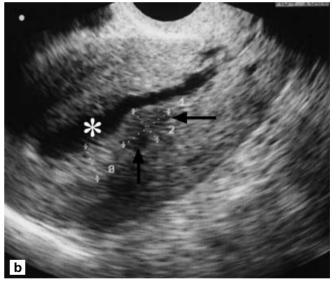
a, b Transvaginal scan of patient with metrorrhagia. a Small hypoechogenic nodule (*arrows*) is seen in close relationship with the endometrial echoes (*arrowheads*). b After distension of the endometrial cavity by hysterosonography (*asterisk*), it is quite easy to demonstrate the lesion (*arrows*) as a small submucosal fibroid
